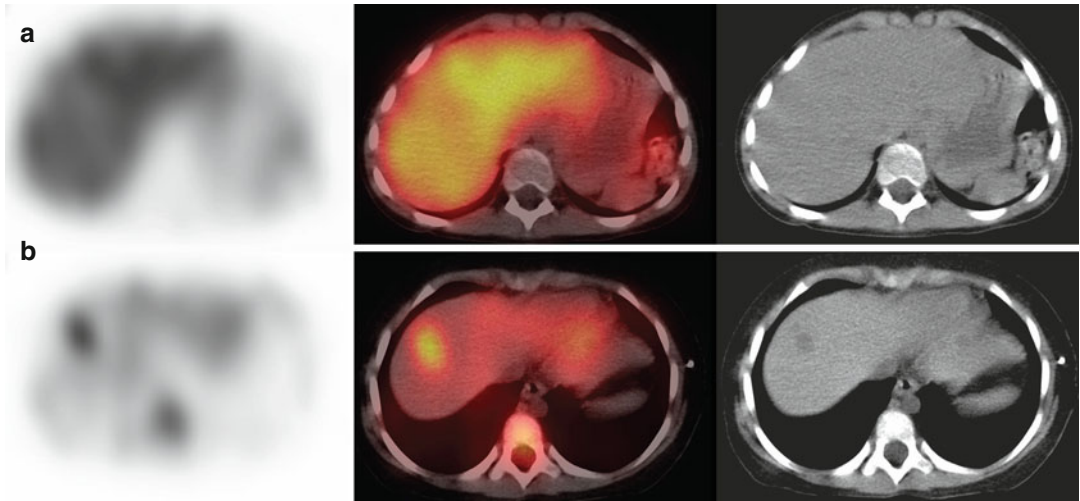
Iodine-123-MIBG SPECT/CT images in two different patients. (a) Relatively increased uptake is seen within the left hepatic lobe, a common normal finding.
